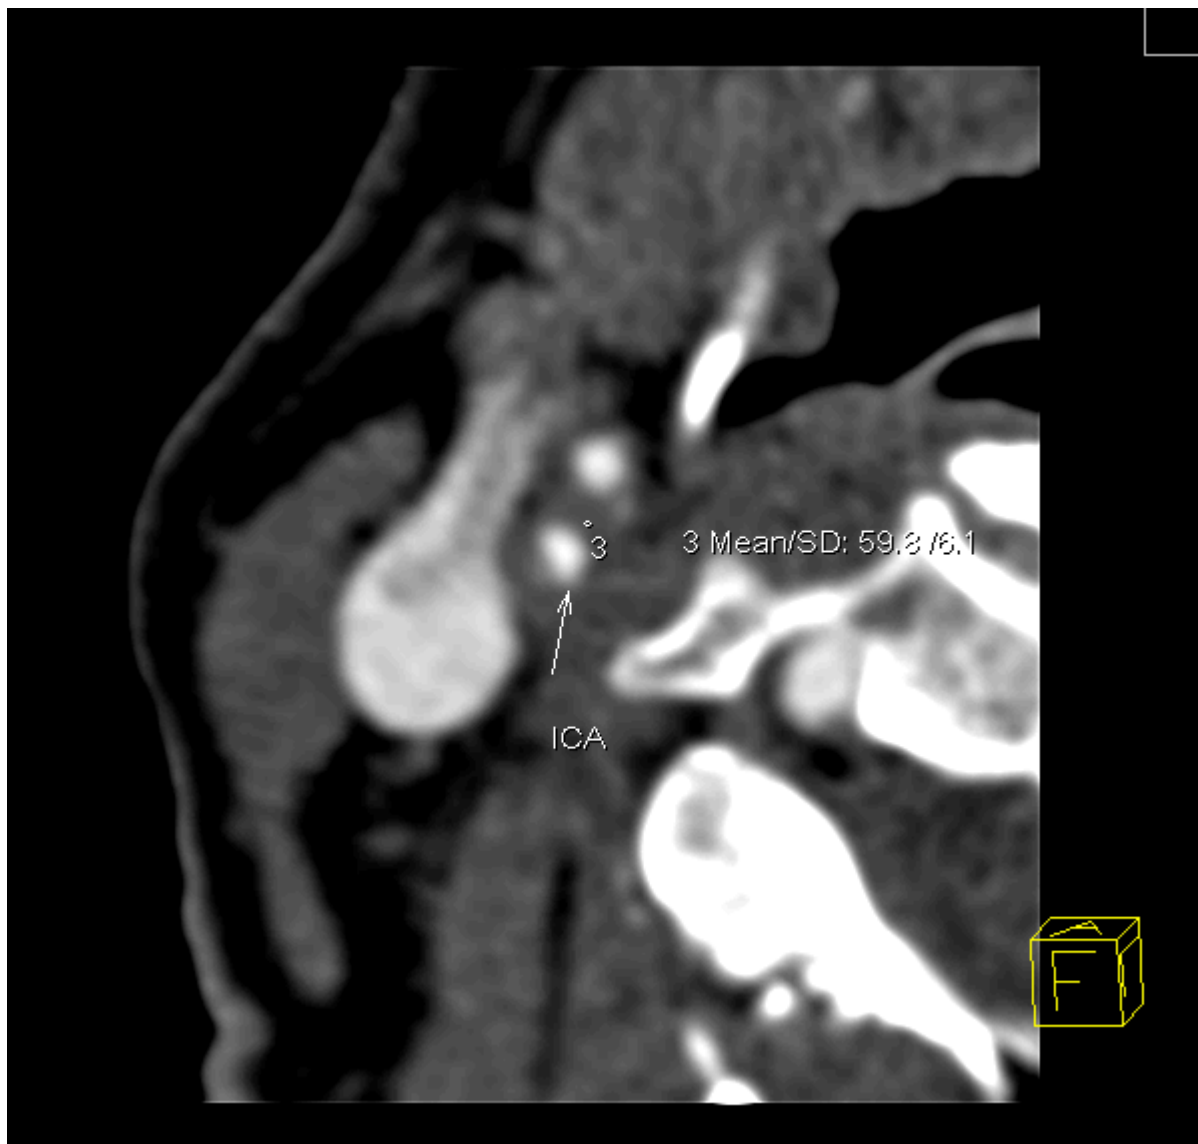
MDCT. Plaque with the least measured tissue density of 59,8 Hounsfield units (HU). ICA-internal carotid artery, MDCT- multidetector-row computed tomography.
